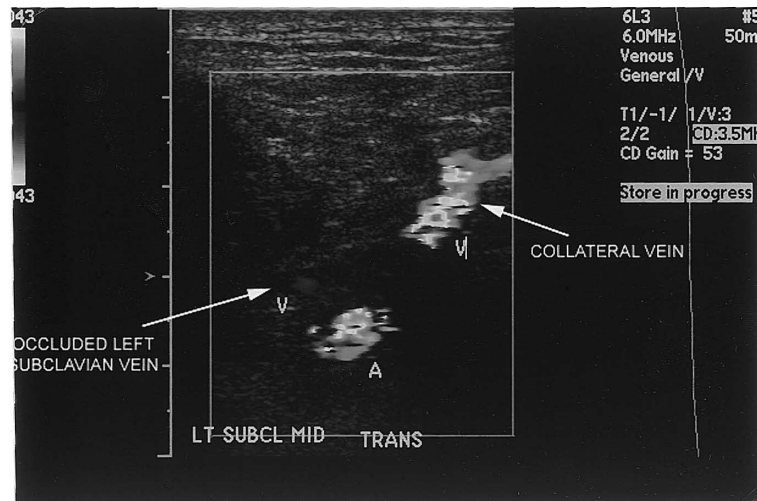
Follow up transverse Doppler ultrasound image through the mid-subclavian vein shows minimal flow consistent with high grade occlusion of the vessel. Normal flow (red color) is seen in the adjacent subclavian artery. Incidentally, the color flow is seen in a nearby collateral vein, which has presumably formed in relation to the chronic DVT.
